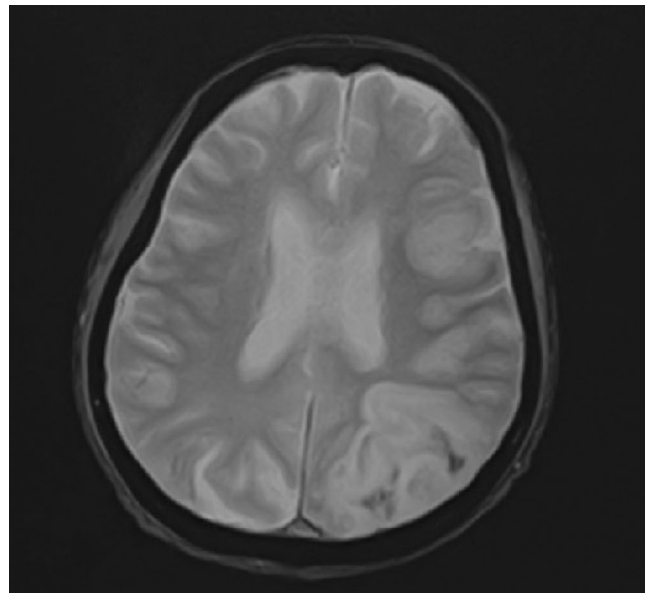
MRI axial SWI image
